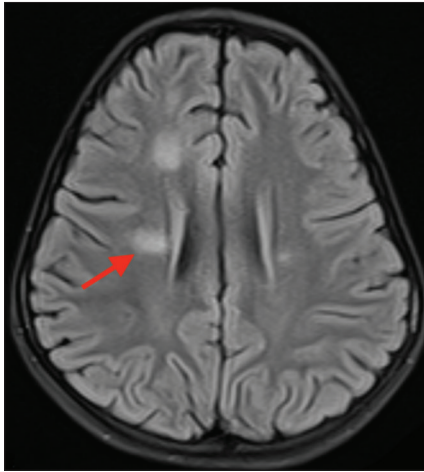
Axial FLAIR magnetic resonance imaging brain showing multiple hyperintense lesions in bilateral periventricular regions (arrow)
